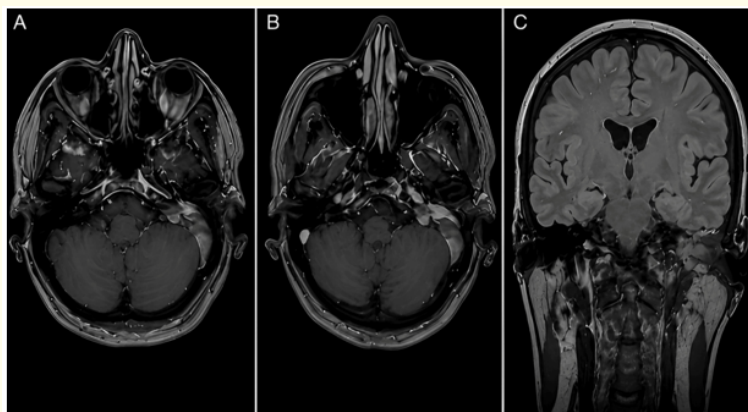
Brain and temporal bone MRI (12/02/2025) showing a stable soft tissue lesion of the left petrous pyramid with locoregional extension.
